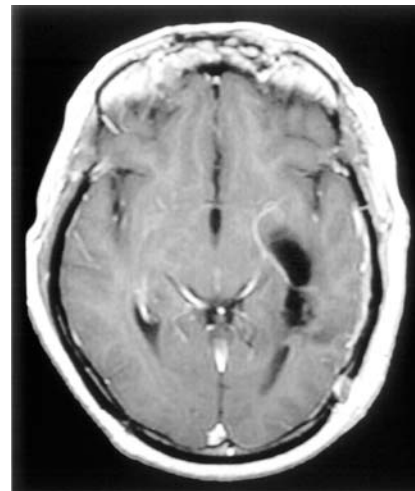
Two-month postoperative MRI scan with gadolinium contrast demonstrating some residual dilatation of the left temporal horn but no evidence of tumor in the left lateral ventricle
